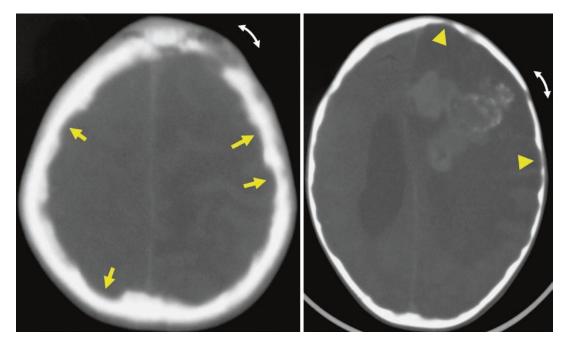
Axial cranial CT scan on bone windows with signs of increased intracranial pressure: prominent impressions on the inner table of the skull (beaten copper
